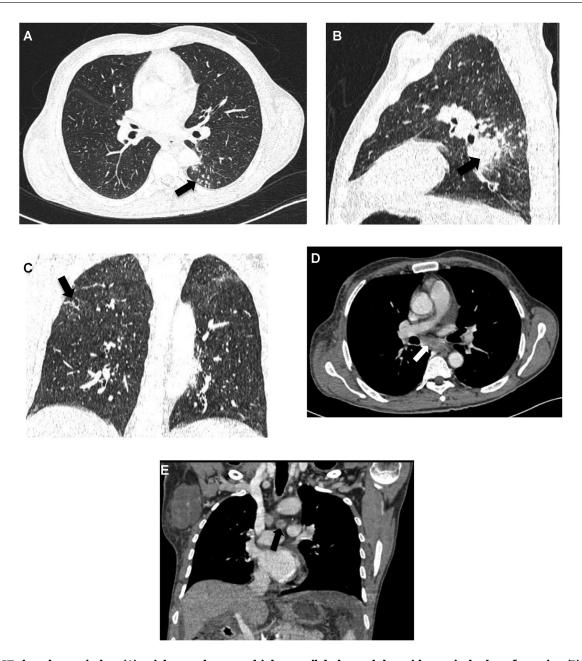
CT chest lung window (A) axial scan shows multiple centrilobular nodules with tree-in-bud configuration (B)Sagittal reconstruction showing confluence of centrilobular nodules forming a patch of consolidation, in posteromedial segment of left lower lobe (arrow). (C) Coronal reconstruction shows small thin-walled cavitary lesion in right upper lobe. (D) axial mediastinal window showing conglomerated subcarinal lymphadenopathy (E), coronal reconstruction (mediastinal window) shows precarinal node with central hypodensity; and right axillary fluid collection.
